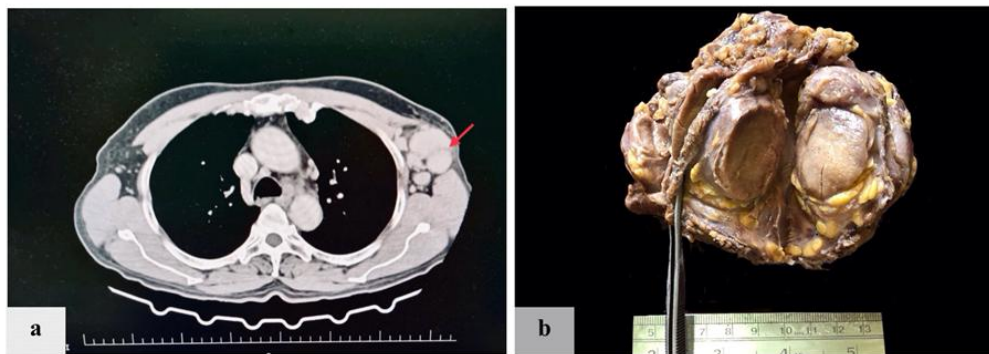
CECT chest radiograph showing multiple, enhancing, enlarged left axillary lymph nodes with a lobulated outline (red arrow) (a). Gross photograph of the excised axillary lymph node mass showing discrete, encapsulated lymph nodes. Cut section is greyish tan, firm (b).
